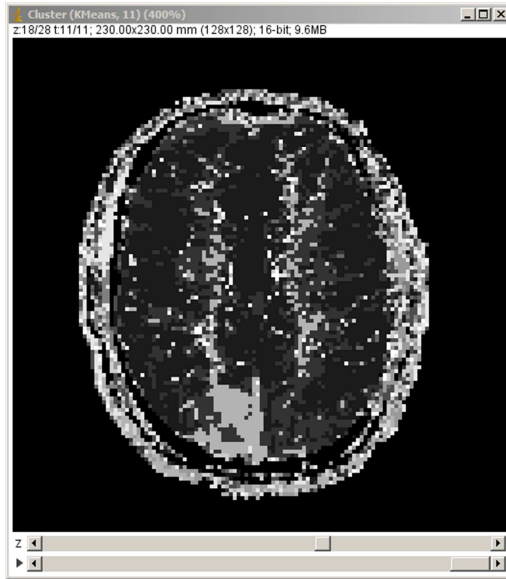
Clustering results for a dynamic MRI study using gadolinium as a contrast agent in a human subject. A lesion can be seen clearly at the bottom of the image. In this case, the full image screen is shown to highlight the ImageJ frame and the dynamic image controls that allow the user to switch between the different classes or, as in this case, a last frame containing all the classes, each with a different gray level.
